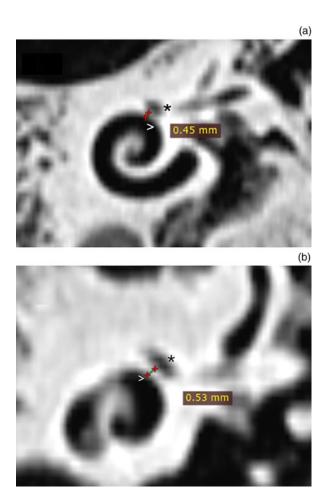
(a & b) Measurement of cochleo-facial distance on double oblique, coronal, high-resolution computed tomography scans of the temporal bone. '*' = labyrinthine segment of facial nerve; '>' = middle turn of cochlea
